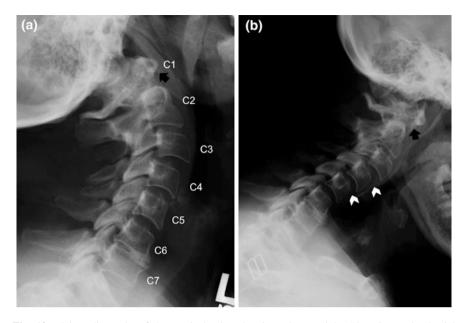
Plain radiographs of the cervical spine showing atlanto-axial subluxation and subaxial subluxation in a patient with rheumatoid arthritis. The lateral views of the cervical spine were taken with neck extension (a) and flexion (b). In the flexion position, a separation of anterior arch of C1 from the dens of C2 (*arrow*) is revealed. This is not observed in the extension position (*arrow*), indicating the presence of dynamic atlantoaxial subluxation. Subaxial subluxation (*arrowheads*) is also present at C3–C4 and C4–C5
